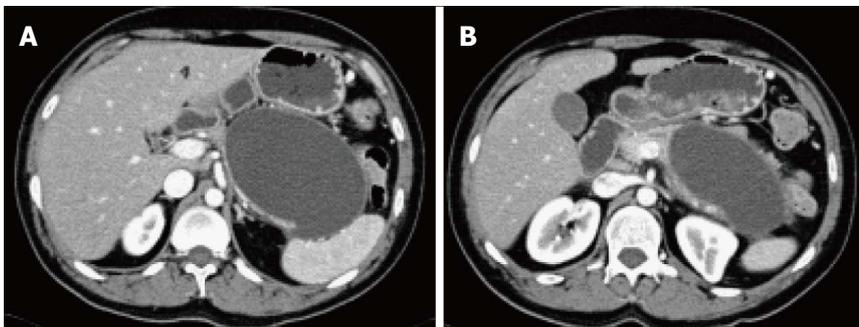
Large pancreatic pseudocyst. A-B: Axial CT scan during the late arterial phase. There is a large oval shaped pancreatic pseudocyst located anterior to the pancreatic body and tail, associated with mass effect on the thinned out pancreatic tissue in keeping with a large pancreatic pseudocyst.
